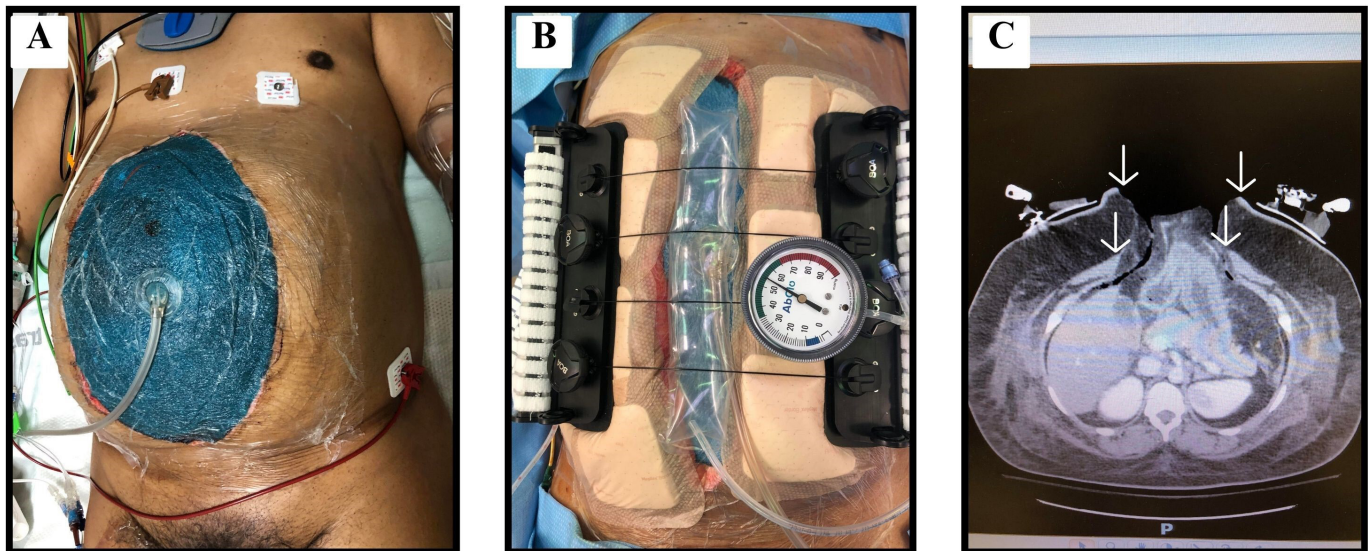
Photograph of the initial fascial gap on an open abdomen covered with a negative pressure wound dressing prior to device placement (A). Reduction of the fascial gap after non-invasive placement of the AbClo device in the same patient (B). Primary fascial closure was achieved after 9 days of open abdomen and two takebacks. Photograph of a CT scan axial view of a different patient showing the rectus muscle splint medialization of all layers of the abdominal wall, from skin to fascia (arrows). Primary fascial closure was achieved despite 19 days of open abdomen and five takebacks; body mass index 50 kg/m² (C).
